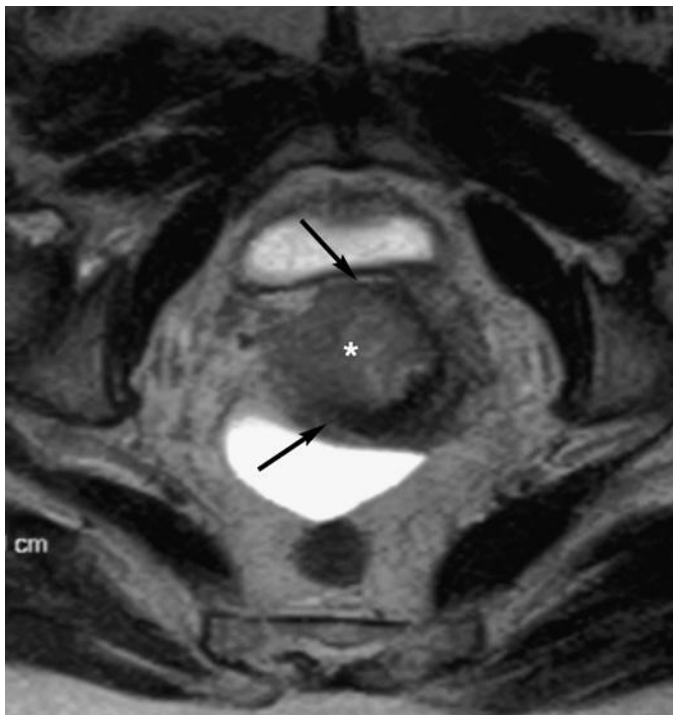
Stage IIB cervical cancer. Axial T2-weighted image. There is interruption of the hypointense ring of cervical stroma (between the arrows) by a large moderately hyperintense cervical mass (asterisk) that bulges into the adjacent fat.
